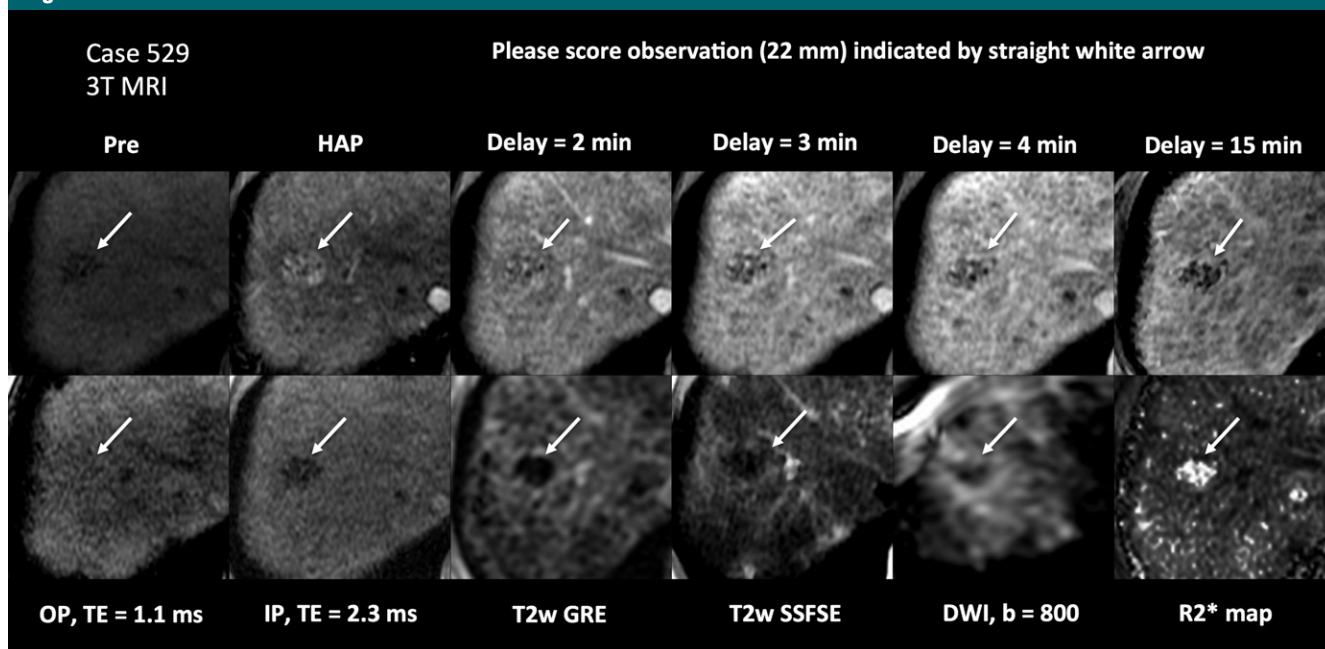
MR image set with low agreement. The image set is exactly as it was presented to reviewers. Although the most frequent response was LR-5, only 36% of reviewers scored this lesion (arrows) as LR-5. *DWI* = diffusion-weighted imaging, *GRE* = gradient-recalled echo, *HAP* = hepatic arterial phase, *IP* = in phase, *OP* = opposed phase, *Pre* = precontrast, *SSFSE* = single-shot fast spin-echo, *TE* = echo time, *T2W* = T2-weighted.
